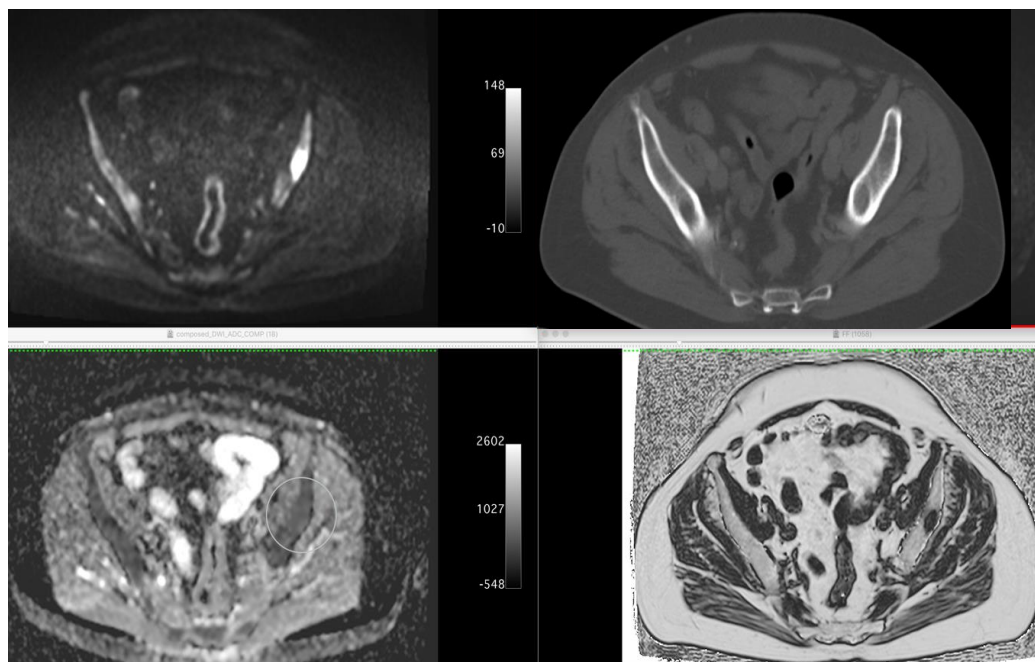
left iliac bone lesion shows high DWI, low FF and low-intermediate ADC, in keeping with active disease. However, the lesion is poorly depicted on CT scan, due to its ill-defined ground glass appearance and a density similar to that of adjacent normal marrow. This image shows how CT scan is not reliable for identifying low density non osteolytic lesions.
